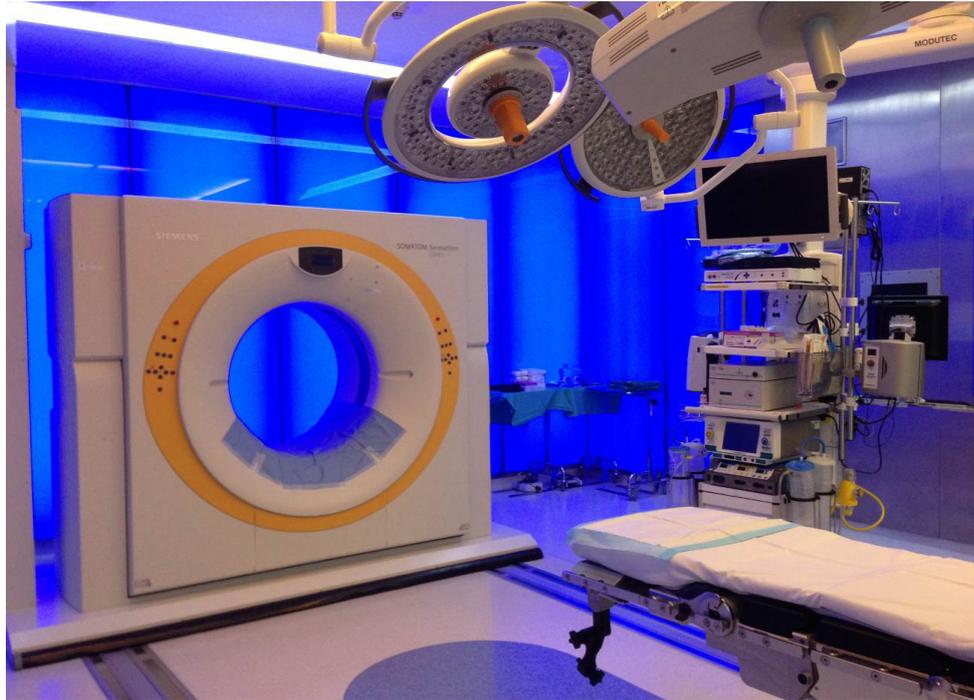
Brainsuite is complete with a floor-mounted sliding CT gantry and radiolucent operating table
